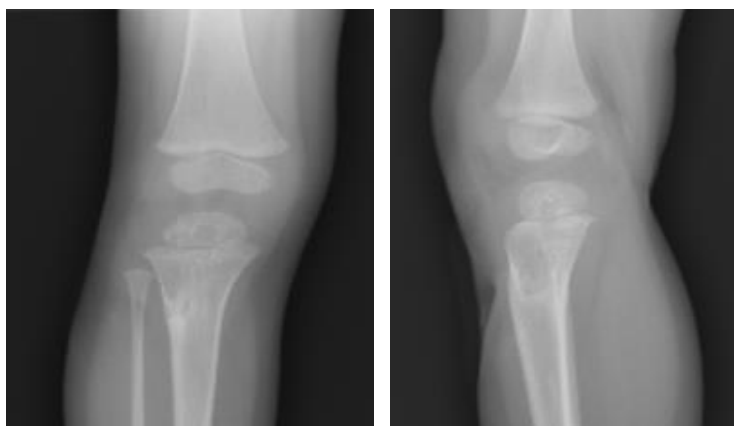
Right knee x-ray AP/lateral view 6 months post operation
